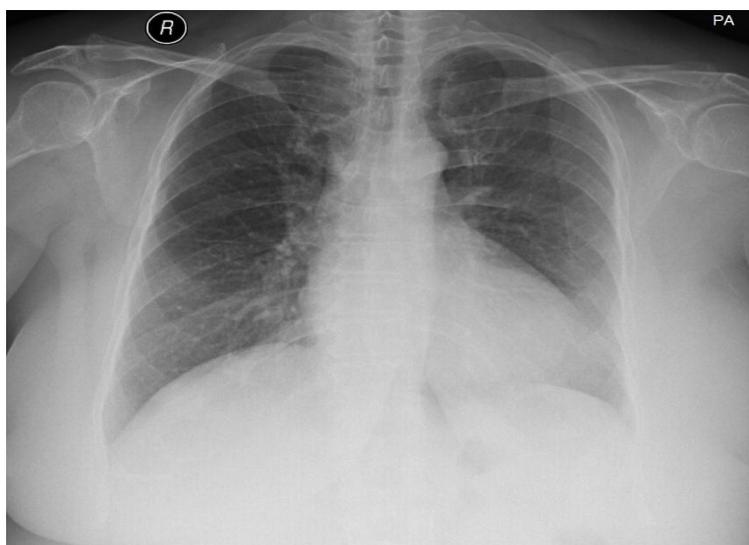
Pre-op normal PA radiograph of chest.
